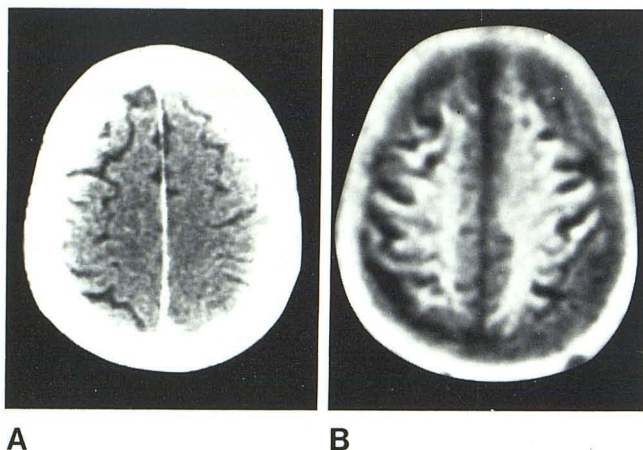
Subdural empyema after surgery. A, Contrast-enhanced CT. B, IR_{1400/400}. Evidence of sulcal compression on right on CT scan (A). Residual fluid or tissue also seen on NMR scan (B).
